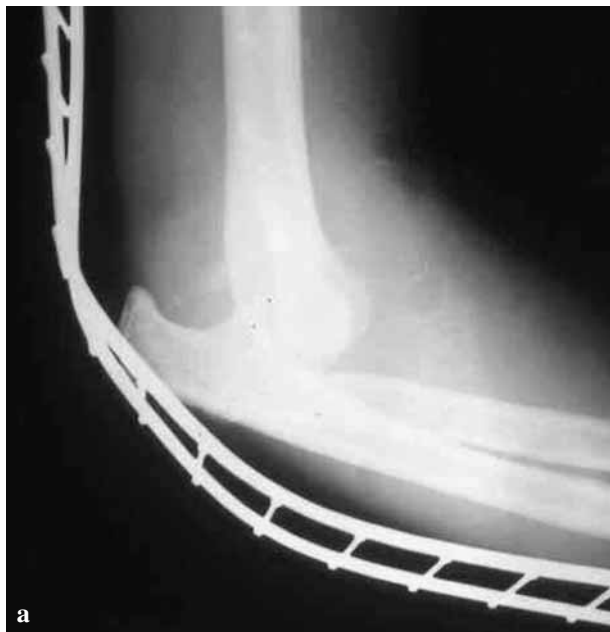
a) Radiograph of a 34-year-old man with unstable elbow joint after posterolateral closed dislocation : Preoperative view ; b) The same patient with the fixation device on the 5th postoperative day : Active flexion position ; c) The same patient : Active extension position on the 5th postoperative day ; d) The same patient three years after the treatment - Active flexion position ; e) The same patient three years after the treatment - Active extension position.
